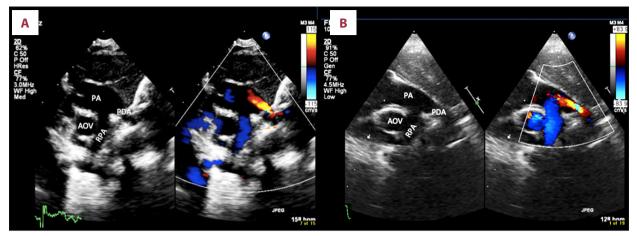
(A, B) Echocardiography showing the main pulmonary artery (PA), right pulmonary artery (RPA), aortic valve (AOV), and patent ductus arteriosus (PDA).
